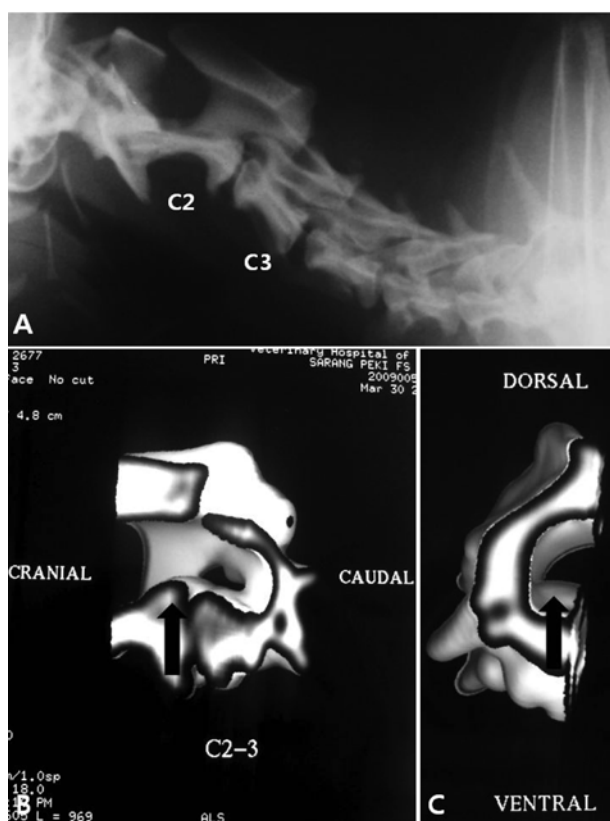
Cervical radiograph and 3-D reconstructed images of a 6-year-old neutered female Pekingese with cervical pain and parietic gait. The survey radiograph (A) shows angulated alignment of C2-C3. (B), (C) 3D reconstruction shows the overgrowth of the vertebral body and also demonstrates prominent impingement of dorsal spur into the vertebral canal (arrow).
